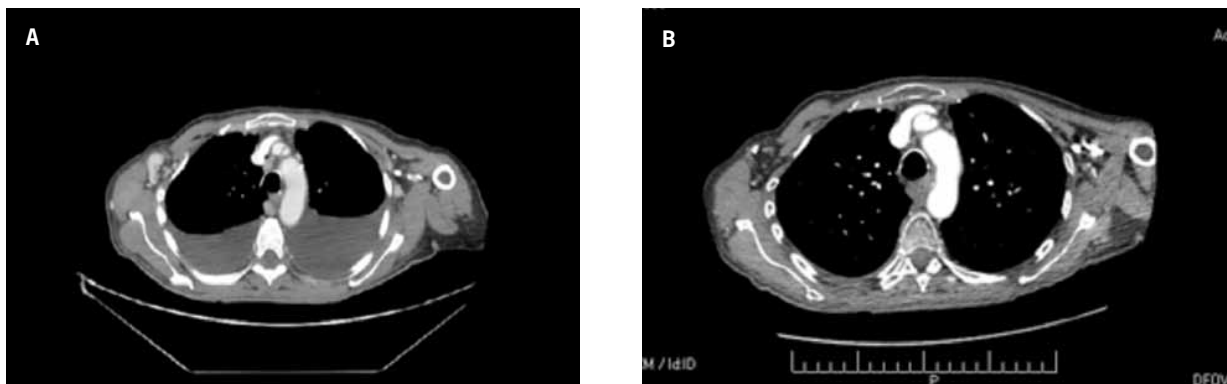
Chest computed tomography scan: (A) before cidofovir and (B) after 3 infusions of cidofovir.
